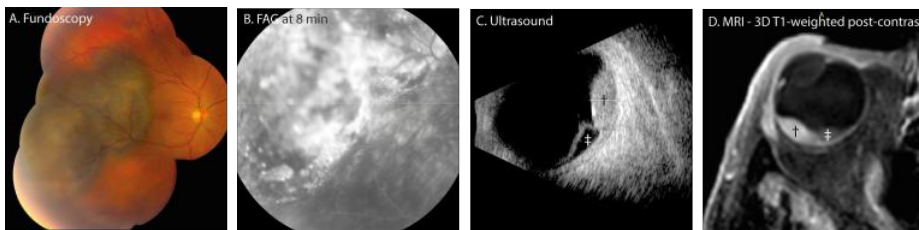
(A-C) Conventional ophthalmic imaging of UM. The fundus photo (A) shows a pigmented lesion. The lesion enhances, shown as pinpoints on the fluorescent angiography (FAG, B). On ultrasound (C), the lesion (dagger) has an intermediate reflectivity, while the retinal detachment (double dagger) has a low reflectivity. On MRI, an enhancing lesion (dagger) with associated retinal detachment (double dagger) are visible (D).
